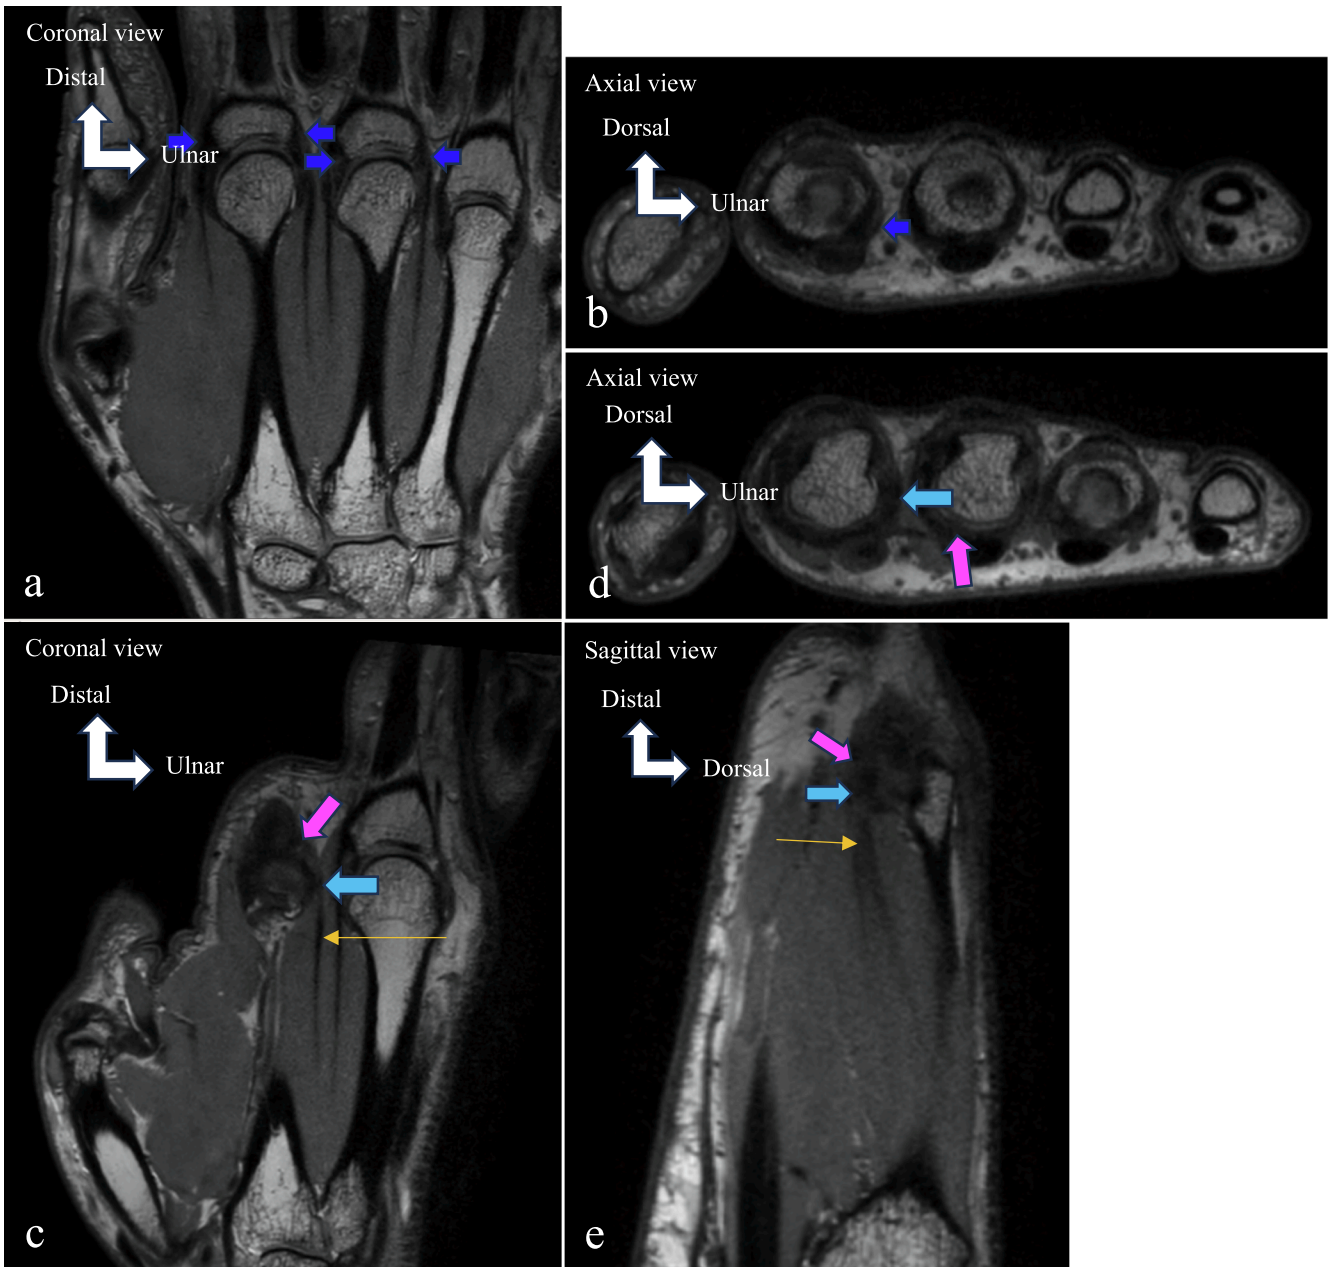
MRI showing the deep distal insertions of the interosseous muscles. Coronal proton density (PD) MRI (a, c), axial (b, d), and sagittal (e) views. Deep insertion of interosseous muscle tendons on the base of the proximal phalanx (a, b, blue arrows). Deep insertion of the first ventral interosseous muscle tendon on the volar plate (c, d, e, light blue arrows). Volar plate highlighted in pink arrows (c, d, e).
